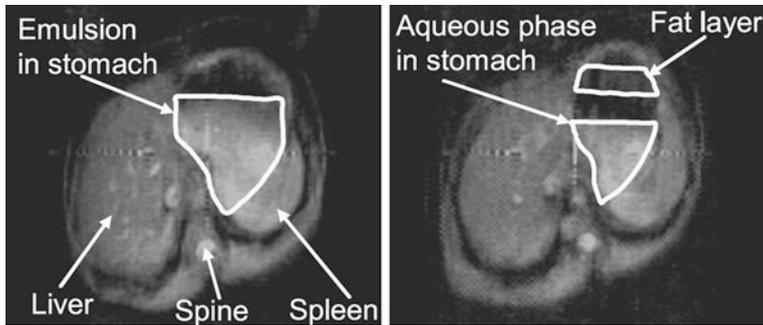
The contrast between fat and water on MRI enables mapping of the spatial distribution of food components within the stomach in a supine subject. Emulsions that are stable to the acidic conditions within the stomach show a uniform distribution of the fatty phase throughout the stomach cavity (*left-hand image*). An emulsion that is sensitive to stomach acid is seen to break forming a layer of oil on the top of the contents (*right-hand image*). (Marciani et al. 2007)
